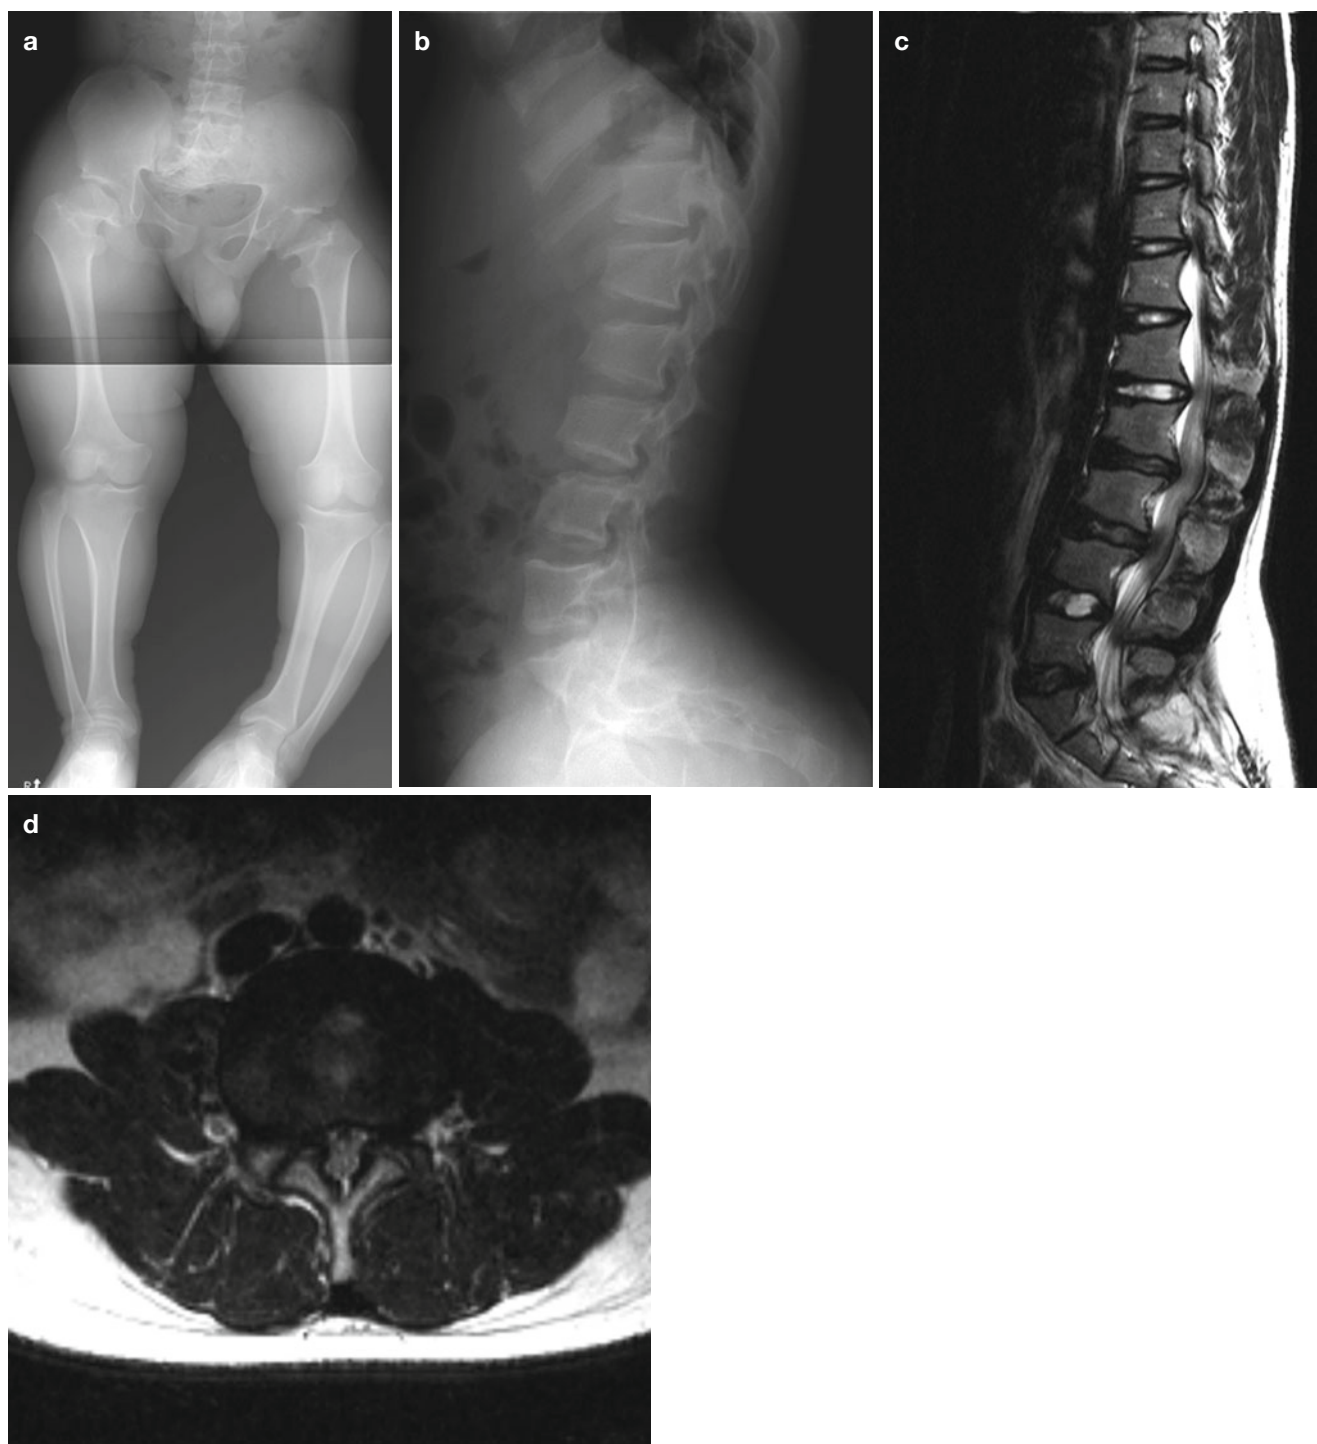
Achondroplasia: adolescent.* (a) Pelvis and lower extremity radiograph of a 17-year-old boy shows typical champagne glass-type pelvic inlet with squared iliac wing and horizontal acetabular roof. Short and thick tubular bones, short femoral neck, and left genu varum deformities are seen in the lower extremities. (b) The lateral view of thoracolumbar
